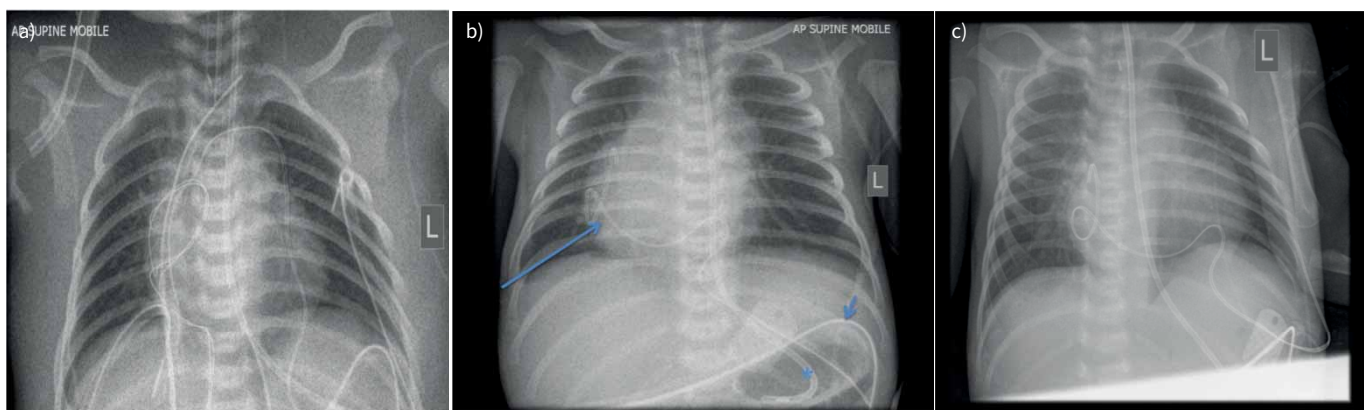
a) Chest radiograph; b) repeat chest radiograph; c) further repeat chest radiograph.
